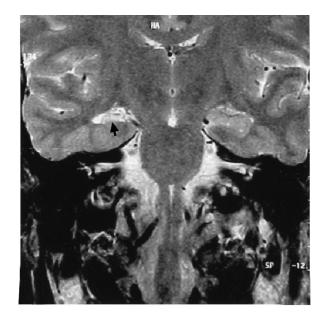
MRI T2WI shows unilateral hippocampal atrophy with mesial temporal sclerosis.
